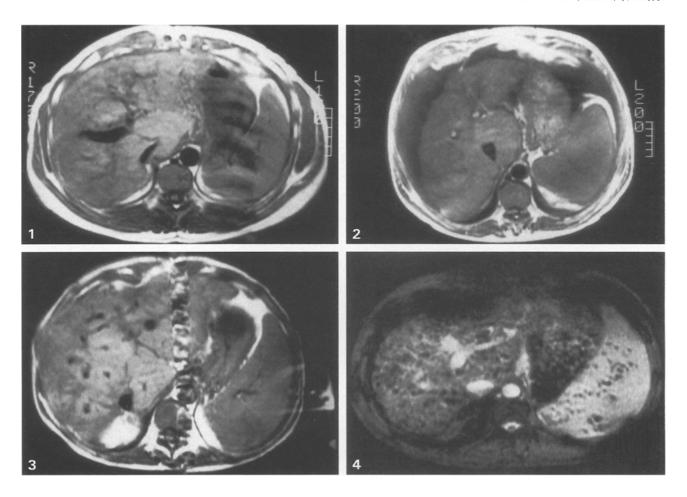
MRI (TE 20, TR 400). Many small hepatic nodules are hyperintense to the surrounding parenchyma. The caudate lobe is also relatively bright.
